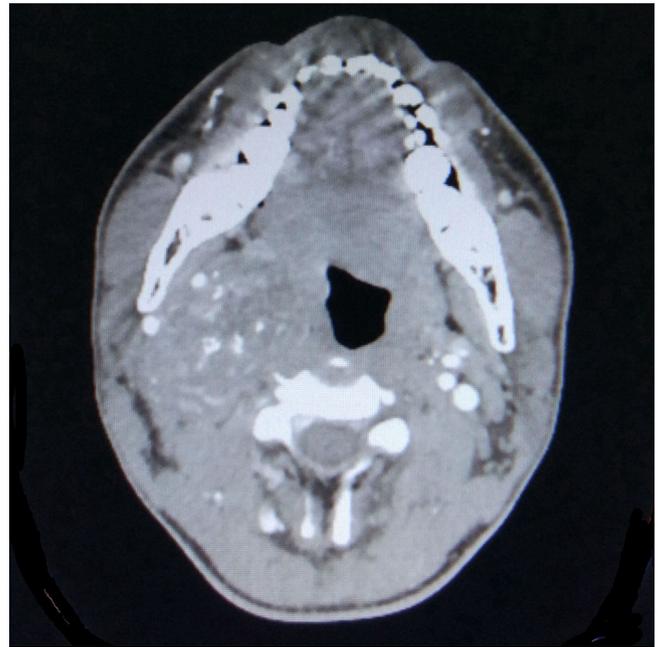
Axial computed tomograph showing radiological features of the tumour compressing the internal and external carotid arteries.
